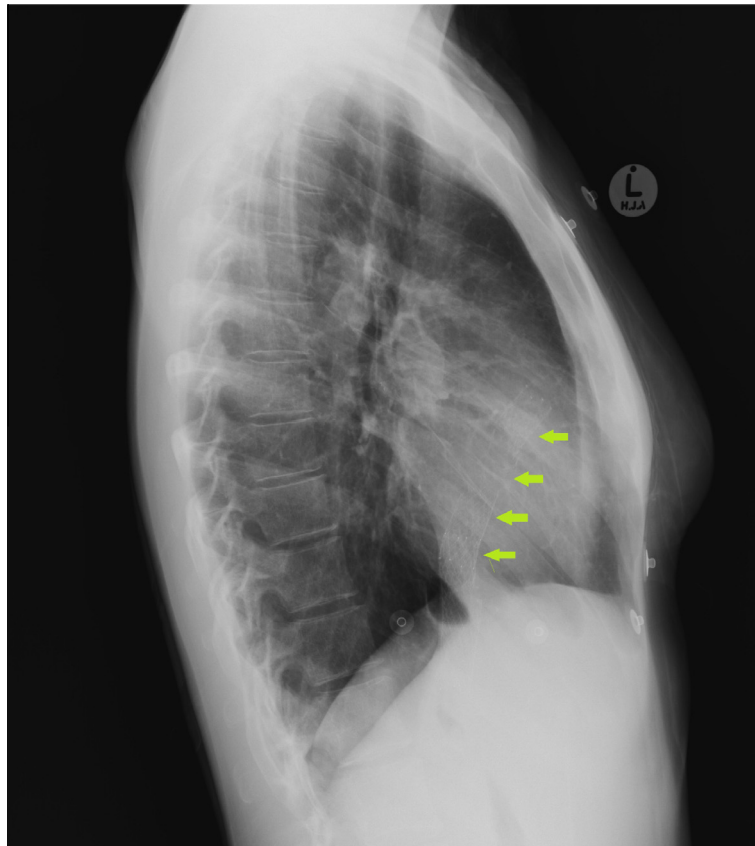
Lateral chest radiograph showing endovascular stent extending into the right atrium.
